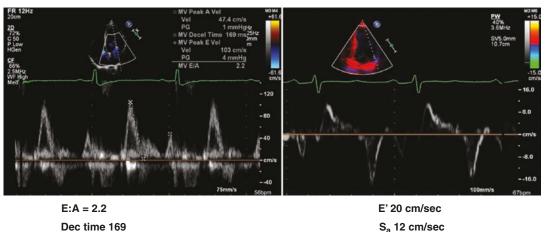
An example of pulsed wave trans-mitral Doppler and pulsed wave tissue Doppler imaging assessing the lateral LV annulus of an athlete. *Sa* systolic annular velocity
